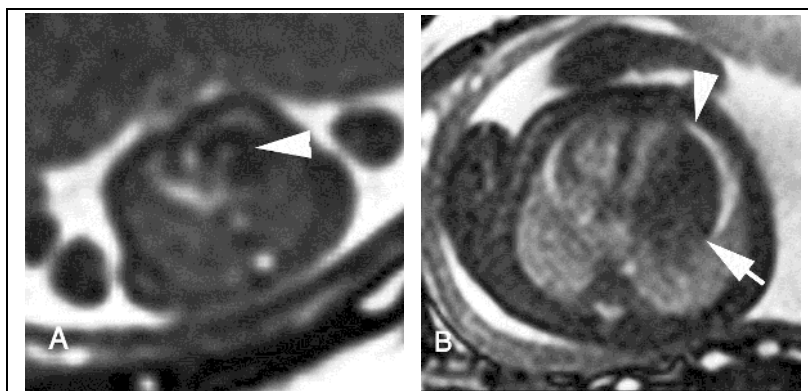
In-utero MR imaging of cardiac rhabdomyomas. (A) Axial T2-SSFP four-chamber view of 16 weeks' gestation fetus show low signal intensity rhabdomyoma of the free left ventricular wall and interventricular septum (arrowhead). (B) Axial T2-SSFP four-chamber view of 26 weeks' gestation fetus shows a large intracardiac mass (rhabdomyoma) within the left ventricle (arrow). Note the associated high signal intensity rim of pericardial effusion (arrowhead).
